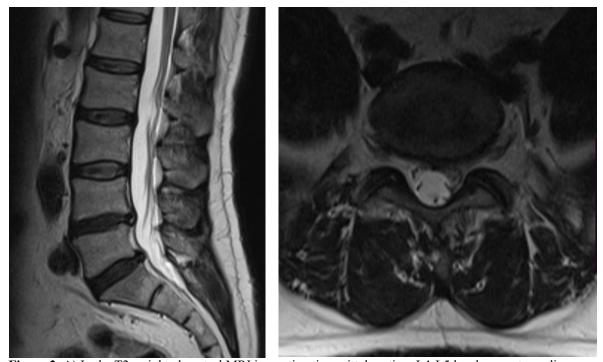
A) In the T2 weighted control MRI inspection, in sagittal section, L4-L5 level sequestrum disc fragment spontaneously regressed. B) In the T2 weighted control MRI inspection in axial section, L4-L5 level sequestrum disc fragment spontaneously regressed
